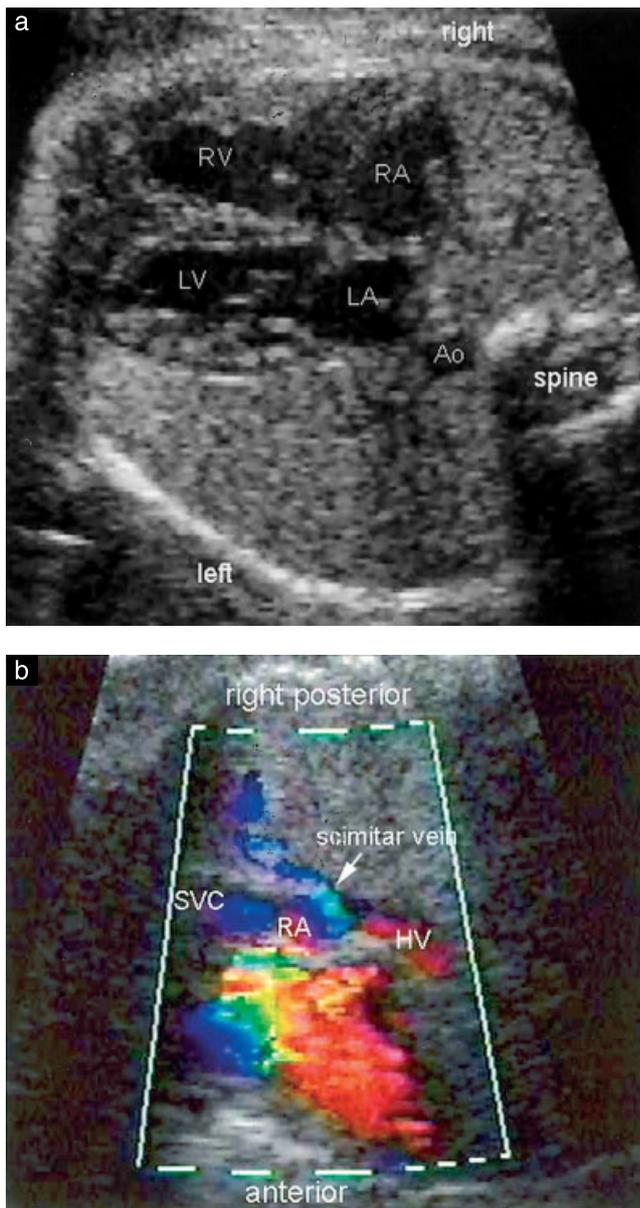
Scimitar syndrome (Case 13). (a) Four-chamber view showing dextroposition of the heart. (b) Color Doppler image in oblique sagittal view shows the scimitar vein. It drains the pulmonary veins from the right lung and enters the lower part of the right atrium (RA) at its junction with the inferior vena cava and hepatic veins (HV). AO, descending aorta; LA, left atrium; LV, left ventricle; RV, right ventricle; SVC, superior vena cava.
